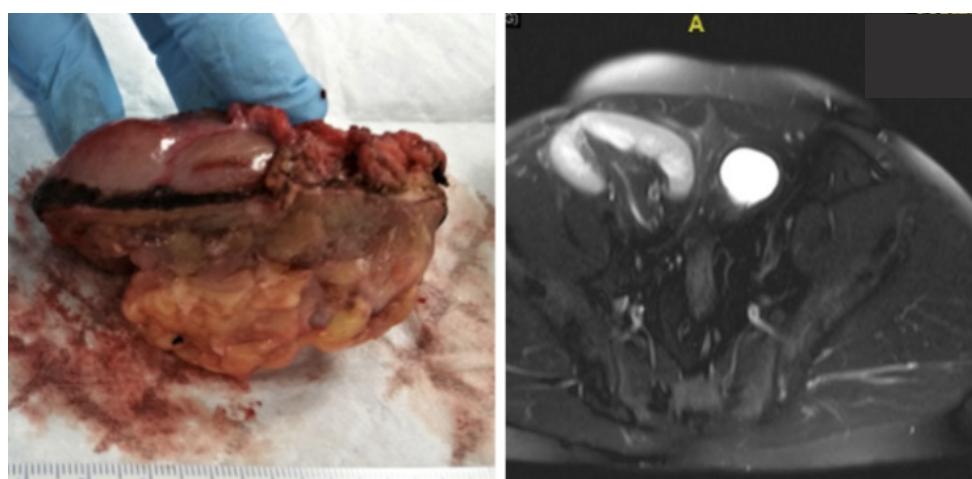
Excision of 4 cm renal mass (left); CT scan of the same patient at 4 year work follow-up, depicting a functional graft (right).
